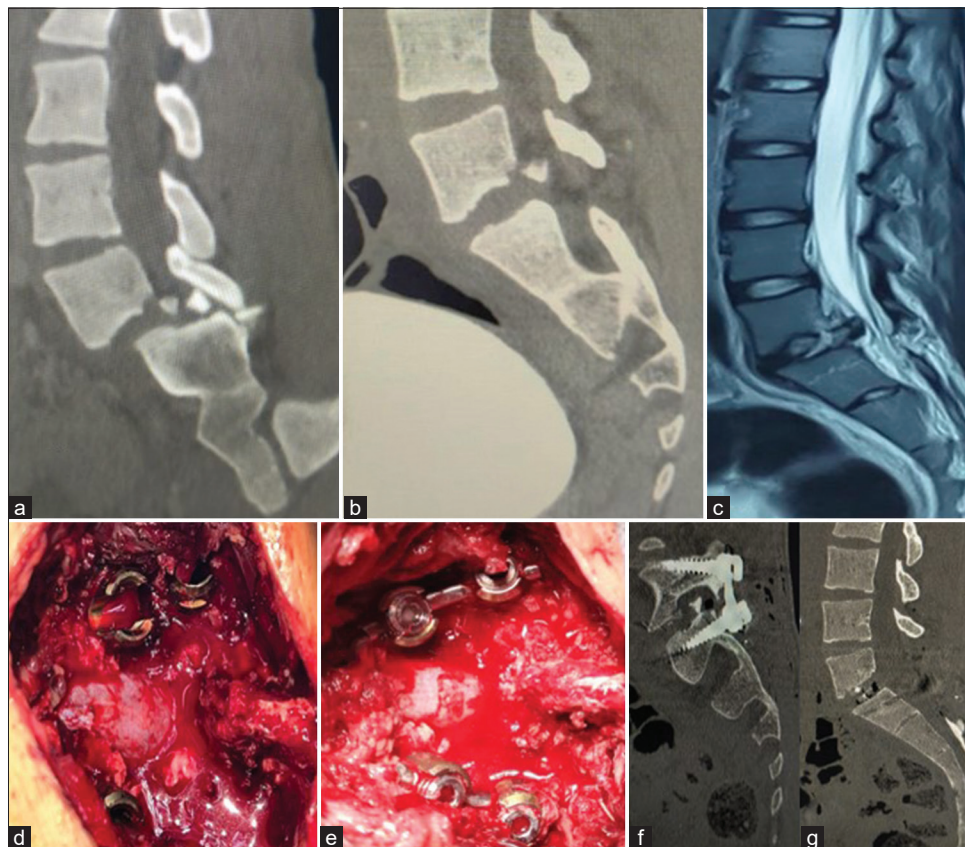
(a) Spine computed tomography (CT) scan showing a fracture of the posteroinferior corner of the vertebral body of L5 with intracanal displacement of the fractured fragment-spondylolisthesis (SPL) grade II L5–S1 and (b) CT scan showing a spontaneous reduction of the SPL. (c) Magnetic resonance imaging: lesion of the L5–S1 disc and (d and e) Intraoperative image before reduction showing a step between the level of the screws at L5 and S1. After placement of the rods, we can see a reduction of the dislocation. (f and g) Pedicle screw fixation of L5–S1 with transforaminal lumbar interbody fusion.
